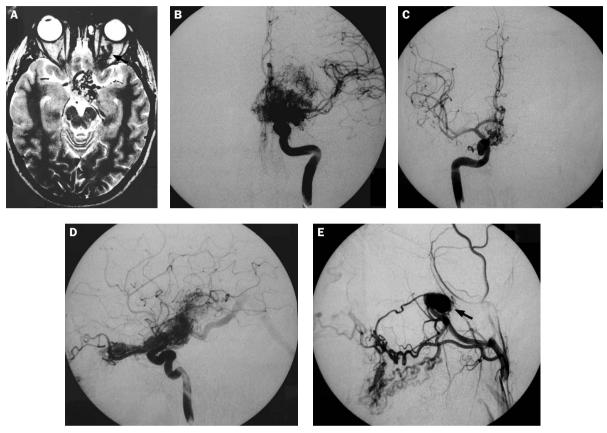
Images of a 28-year-old man with the complete form of Wyburn-Mason syndrome, involving the face, orbit and brain. (A) Axial T2-weighted image shows arteriovenous malformations (AVMs) at the left orbit (arrow) and midline of the hypothalamus. (B, C, D) Bilateral internal carotid angiograms demonstrate AVMs involving the left orbit and midline of the hypothalamus and thalamus, which were supplied by the ophthalmic artery and perforating branches of the middle and anterior cerebral arteries, draining to the internal cerebellar vein to the straight sinus. (E) Left external carotid angiogram depicts maxillary AVMs associated with aneurysmal formation in the pterygopalatine segment of the internal maxillary artery (arrow).
